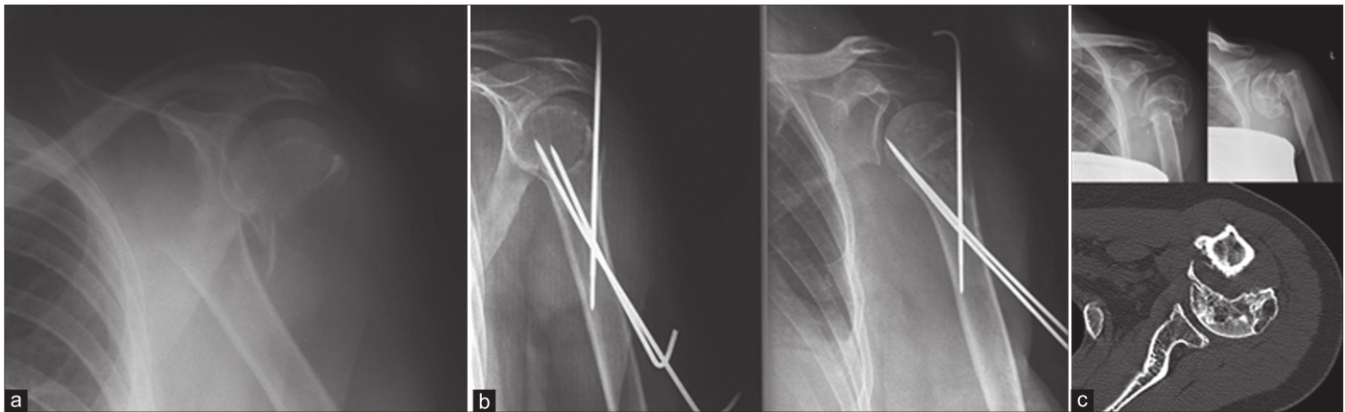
X-ray (anteroposterior view) left proximal humerus in a 36-year-old woman showing (a) 2-part proximal humerus fracture; (b) postoperative X-rays with adequate reduction of the fragments and k-wires *in situ*; (c) X-rays and CT scan at 8 years followup with loss of reduction and atrophic nonunion patient was asymptomatic
